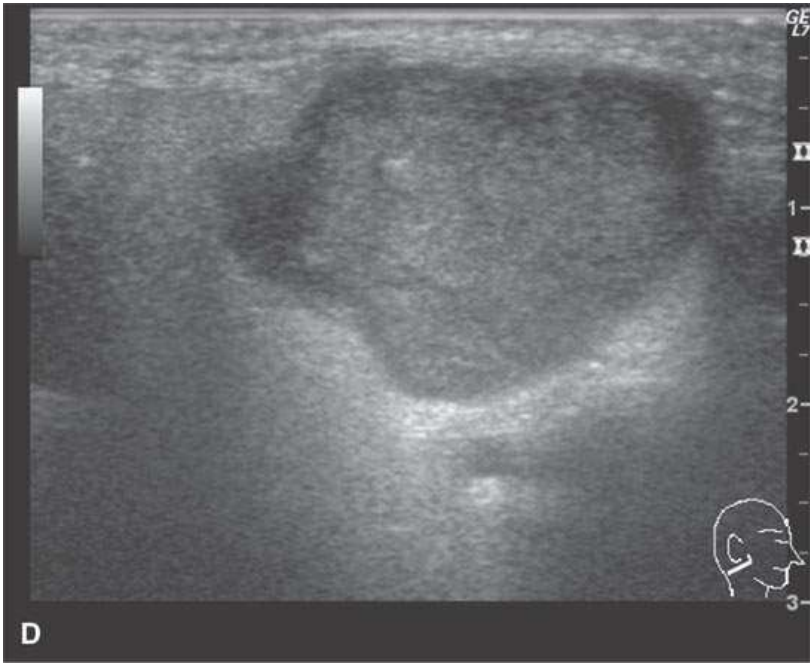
Magnetic resonance imaging and ultrasound of a patient with a benign mixed tumor. The behavior as seen on a T1-weighted non-contrast-enhanced image (A), T2-weighted image (B), and short T1 inversion recovery (STIR) image (C) are consistent with the microcystic structure of this benign neoplasm. The B-mode ultrasound image (D) also reflects the microcystic morphology, but the color flow image shows obviously internal vascularity consistent with the diagnosis of a neoplasm.
